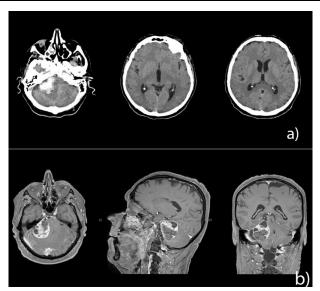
(A) CT scan conducted in a county hospital reveals a hematoma in the right CPA angle without signs of hydrocephalus. (b) MRI with T1 MPRAGE sequence verified the presence of hemorrhage of tumorous etiology (vestibular schwannoma) in the cerebellopontine angle (CPA).
